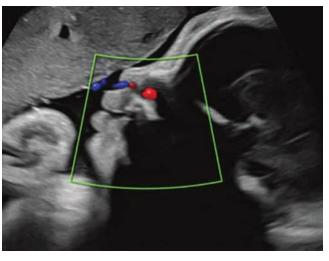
A sagittal color Doppler image displays the movement of amnionic fluid through the nares during fetal breathing.
